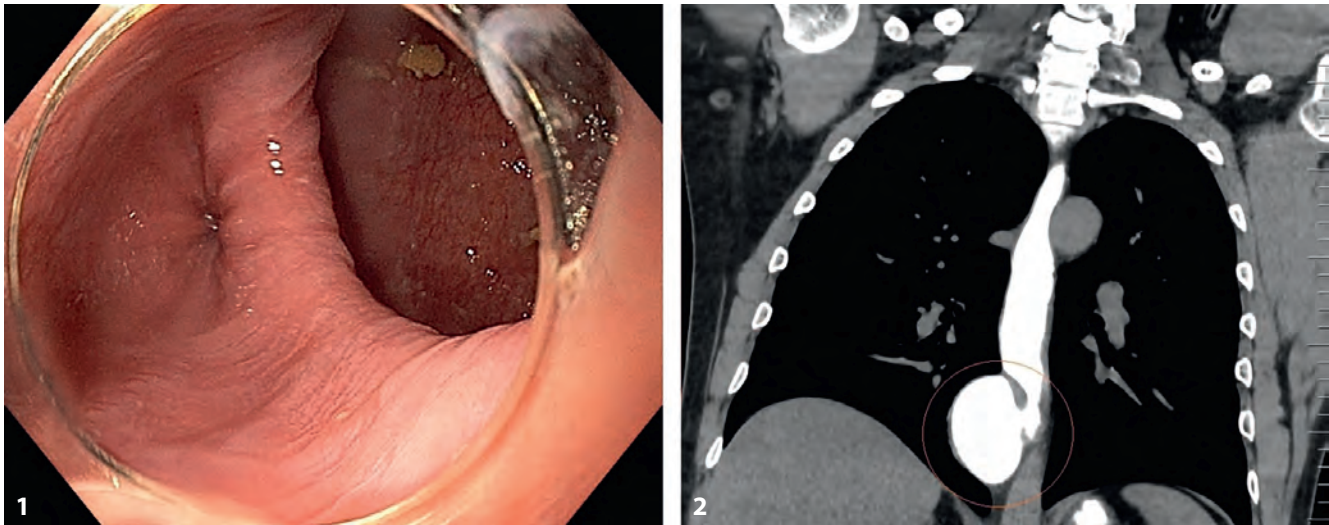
1 — visualization of the diverticulum during video gastroduodenoscopy, 2 — Chest CT with per-oral contrast coronal section view of the diverticulum
